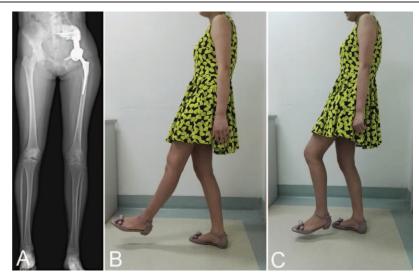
Patient 3 y after surgery. (A) Postoperative plain film showing equal limb length with no loosening, fracture, or dislocation. (B, C) Showing the patient had a relatively satisfying limb function.
